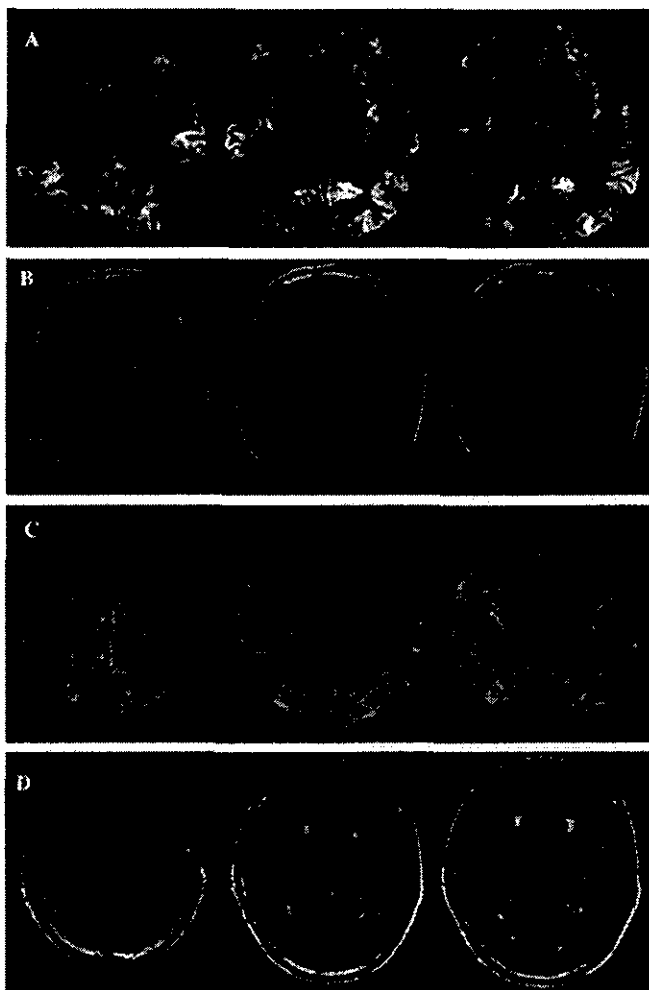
Brain MRI in Patient 2 at 16 months after the onset (A, B) and Patient 8 at 7 months after the onset (C, D). A and C are diffusion-weighted imaging (DWI), and B and D are fluid-attenuated inversion recovery (FLAIR) imaging. In Patient 2, DWI shows hyperintense signals in the bilateral frontal, parietal, and occipital cortices (A), and FLAIR imaging also shows slight hyperintensity signals within the cortical DWI lesions (B). In Patient 8, DWI and FLAIR imaging reveal no distinct abnormal signals in the brain (C, D).
